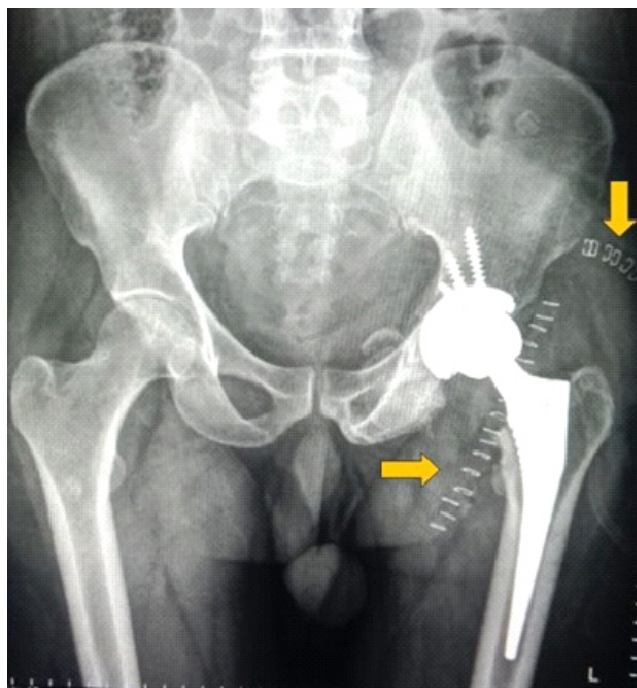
Post-operative radiograph after total hip arthroplasty. Two incisions can be appreciated with two suture lines (yellow arrow).
